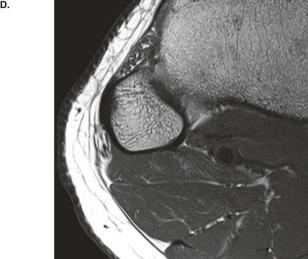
Figure Sc12. MRI scans at the distal third of the thigh through the sciatic nerve and its terminal branches
